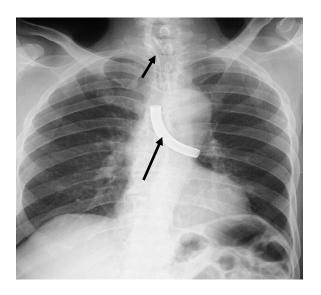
PA Chest X-Ray Showing Metallic Tracheostomy Tube in left main bronchus and Plastic Tracheostomy tube in situ.
